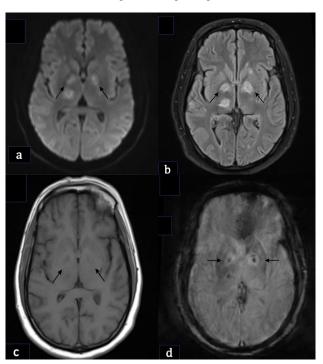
(a) MRI axial diffusion and (b) flair images show symmetric diffusion restriction involving globus pallidi with corresponding flair hyperintensities with right thalamus acute infarct. (c) T 1 weighted image was normal. (d) SWI image shows punctuate haemorrhages within globus pallidi. SWI: Susceptibility weighted imaging.
